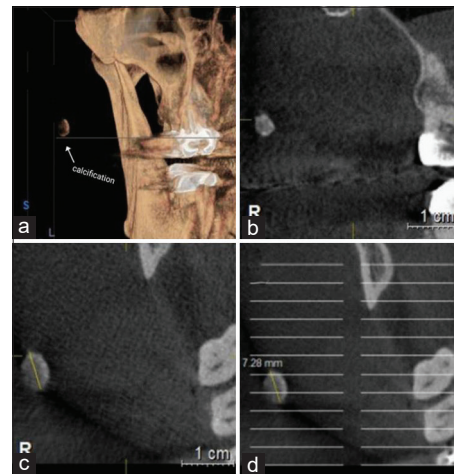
Cone beam computed tomography (a) three-dimensional reconstruction, (b) coronal cut, (c) axial cut, (d) axial cut showing the exact calculation thickness of 7.28 mm
